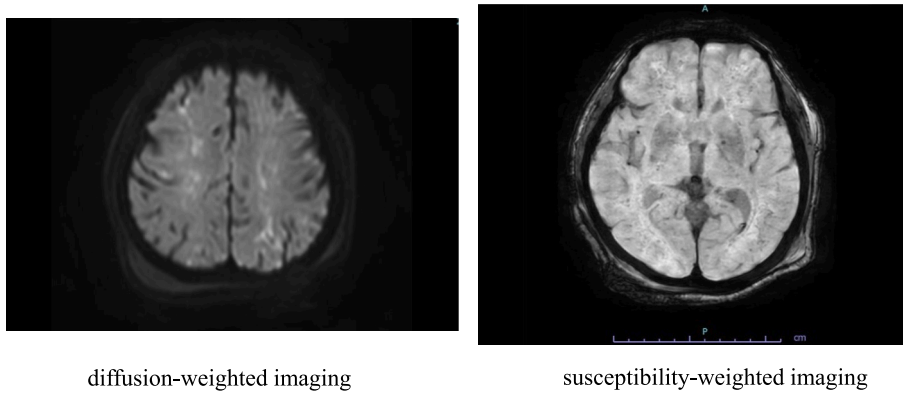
MRI on day 6 revealed diffuse high-intensity areas on diffusion-weighted imaging and several microbleeds consistent with the “walnut kernel” pattern on susceptibility-weighted imaging.
